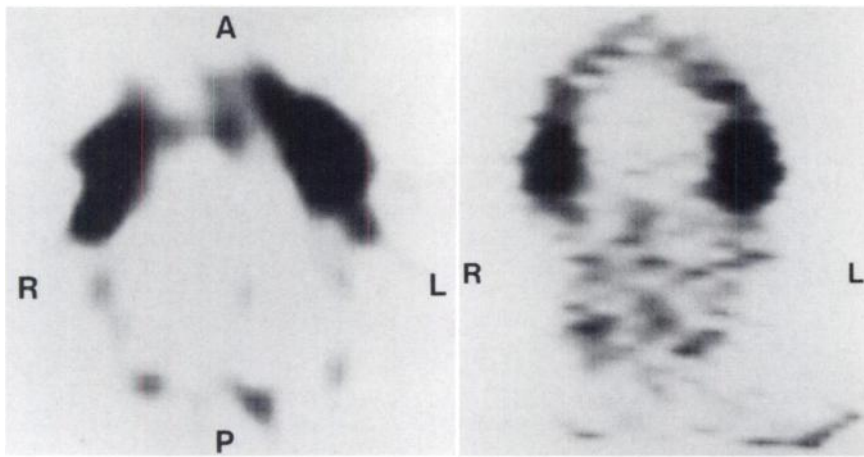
Transverse (left) and coronal (right) SPECT images (6.4-mm sections) of head obtained 2 d after infusion of ^{111}In -2IT-BAD-Lym-1 in patient shown in Figure 1 show intense uptake in tumors. (R = right; L = left; A = anterior; P = posterior [aspect of patient]).
